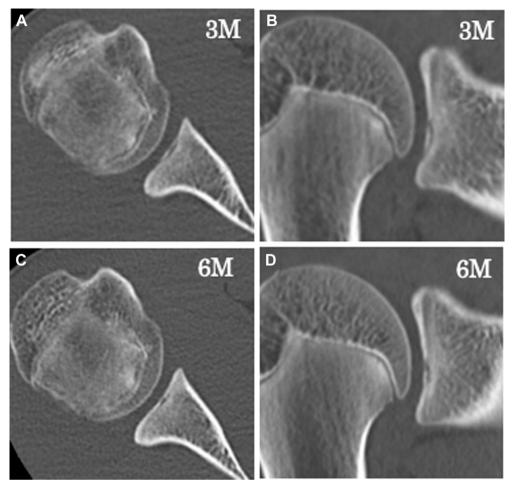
Computed tomography 3 months (A, B) and 6 months (C, D) after the first visit showed improvement in the lesion.
